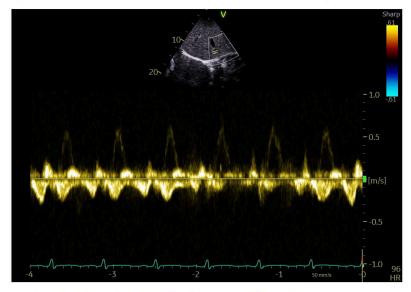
normalization of hepatic vein Doppler flow after fluid removal.
